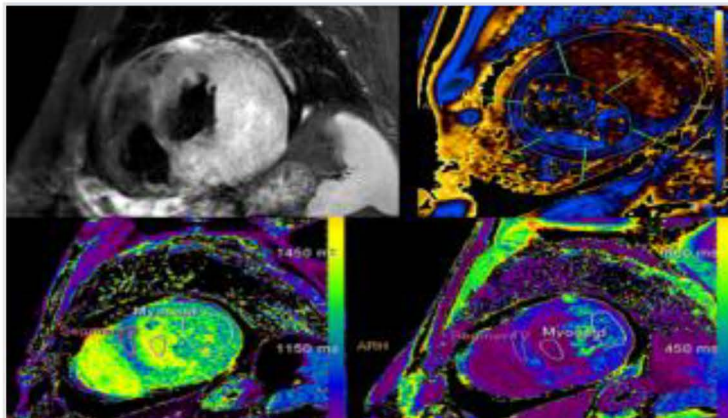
At the mid-ventricular level, T2-weighted STIR sequence (A) demonstrates hyperintensity within the myocardium, more prominent in the free wall, suggestive of edema or inflammation. Corresponding T2 (B) and T1 (C) mapping values at the same level show increased values, again more marked in the free wall
